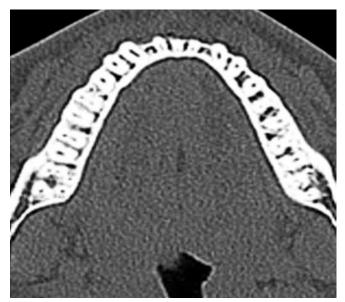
CT scan slice reveals four separate roots (RP, ML, DB and RE) and five separate (MB-1, MB-2, ML, DB, RE) canals at middle third
